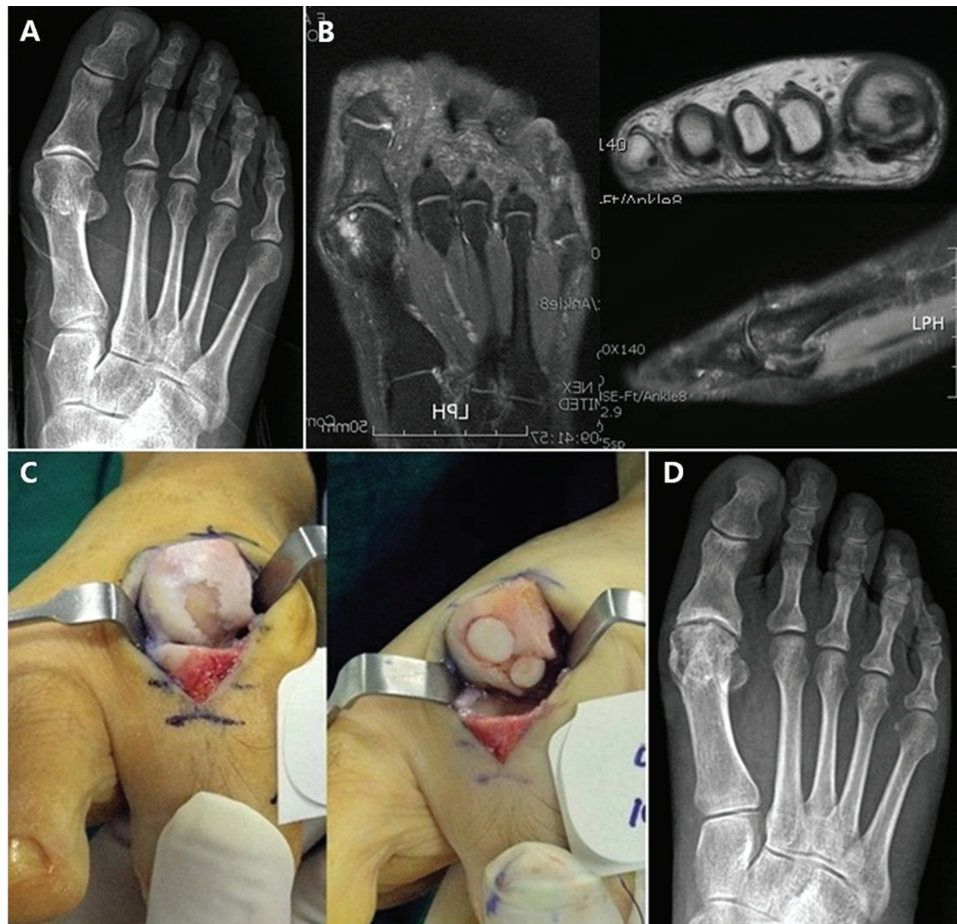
(A) Preoperative anteroposterior radiograph of the right foot. (B) Magnetic resonance imaging scans. T2-weighted coronal and sagittal images showing the osteochondral defect, subchondral cyst, and subchondral bone edema of the first metatarsal head. T1-weighted axial image showing the defect of the first metatarsal head. (C) Intraoperative photographs. Two osteochondral plugs were impacted in the defect site, and subchondral drilling was performed at the uncovered site between the impacted 2 plugs. (D) Anteroposterior radiograph of the right foot at 9 months after the operation. Degenerative arthritic change was observed in the first metatarsophalangeal joint.
